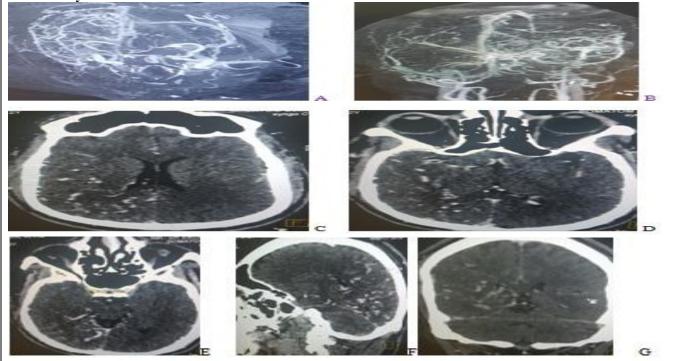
CT Cerebral digital subtraction angiography (A,B) showing diffuse proliferative angiogenesis. Post contrast CT (C,D,E,F,G) brain axial, sagittal and coronal images showing diffuse network of densely enhancing vascular channels in right posterior parietal, right temporo-occipital region with intervening normal brain parenchyma. No dominant feeder artery is seen.
